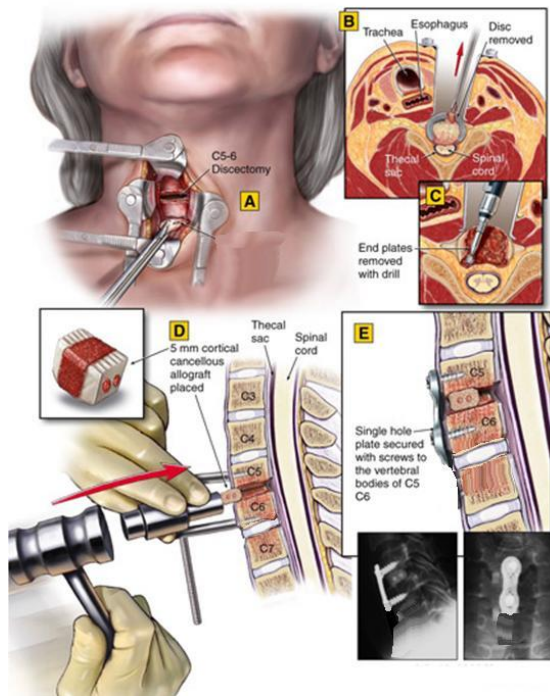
Dissection of the neck to anterior vertebrae A, Cross-sectional view of A: B, Vertebral endplate debridement C, Inter-positional graft insertion D, Buttress plate application E with X-ray results.²⁰
